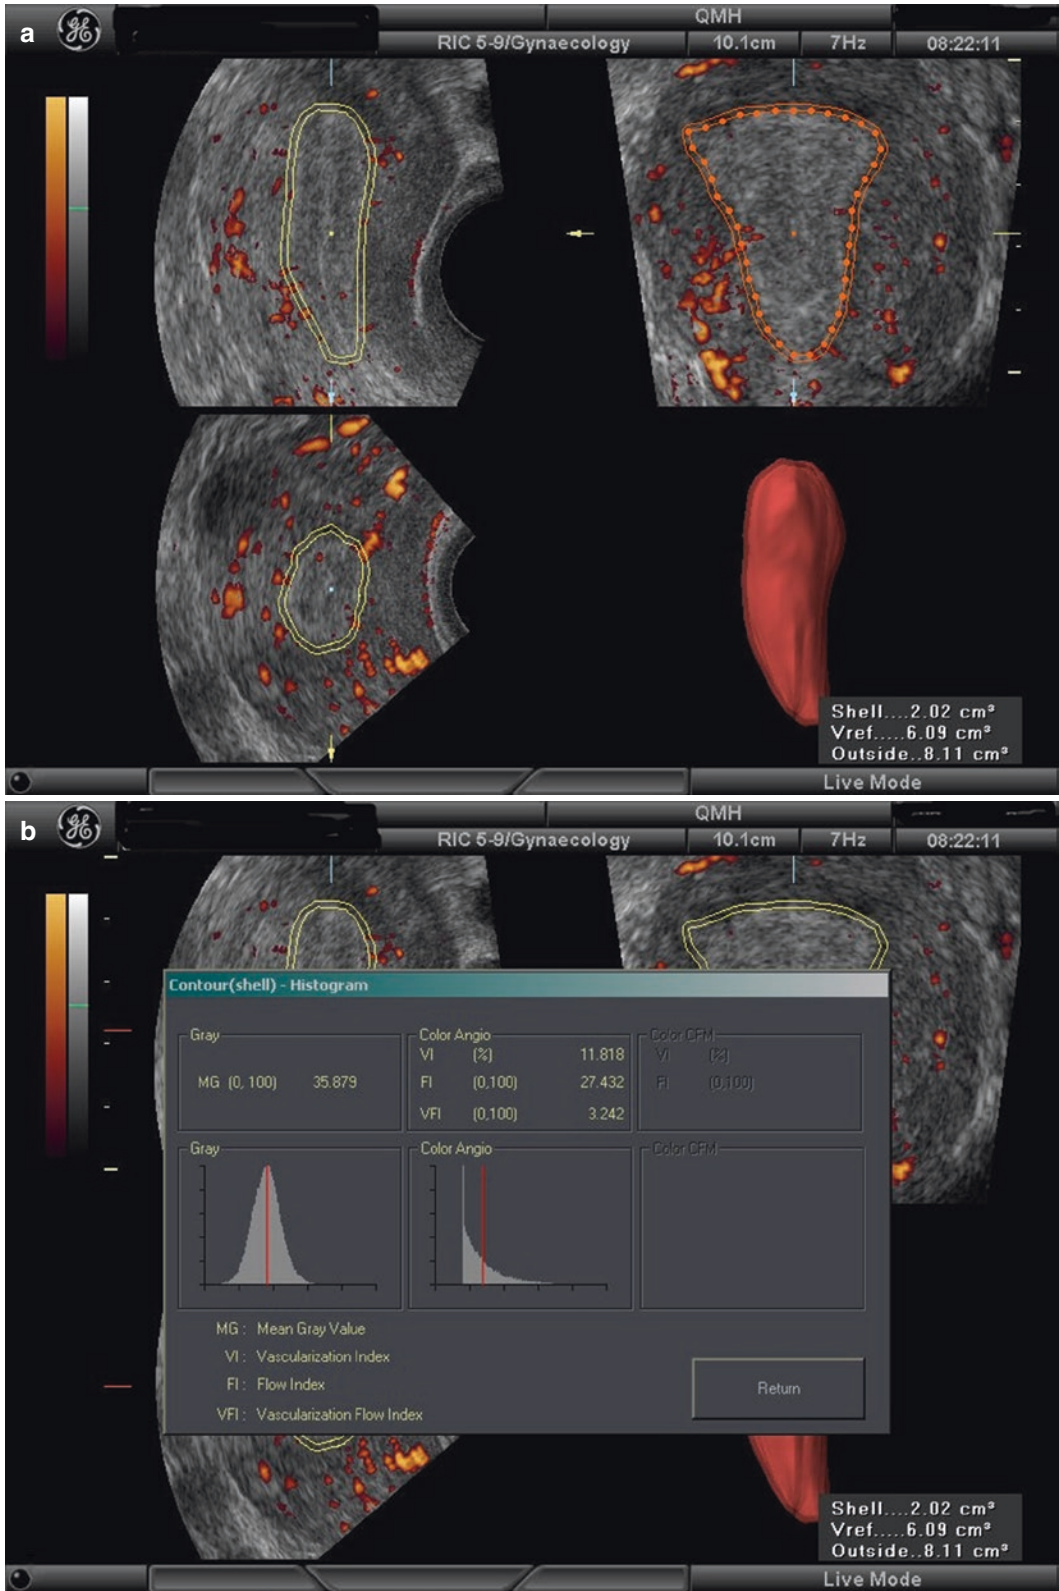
(a, b) Subendometrial volume and blood flow measured by 3D Doppler ultrasound
